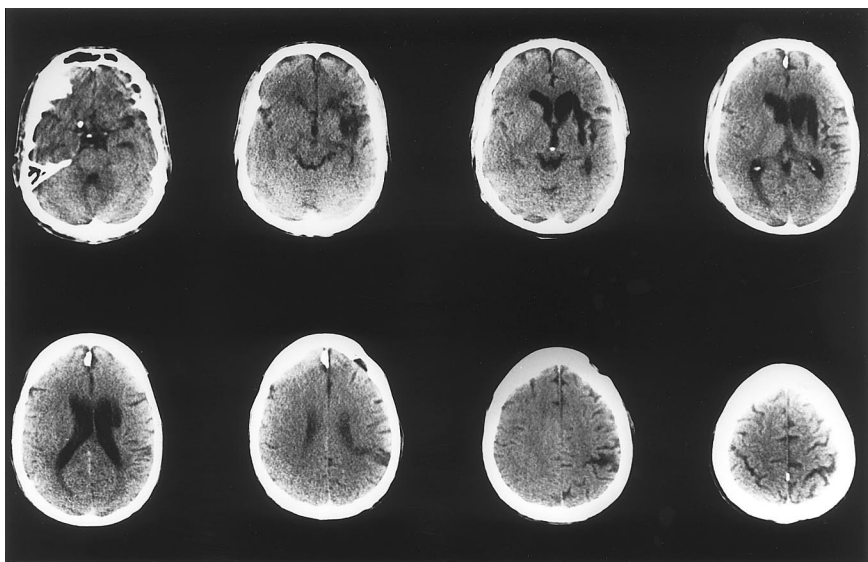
CT scan from 2 years postonset reveals an area of infarction in the left lenticulostriate territory involving putamen, dorsolateral caudate, the lateral anterior limb of the internal capsule, and anterior periventricular white matter. There is a separate small lesion in the mid parietal lobe. These left-hemisphere lesions are on the right side of the CT scan.
